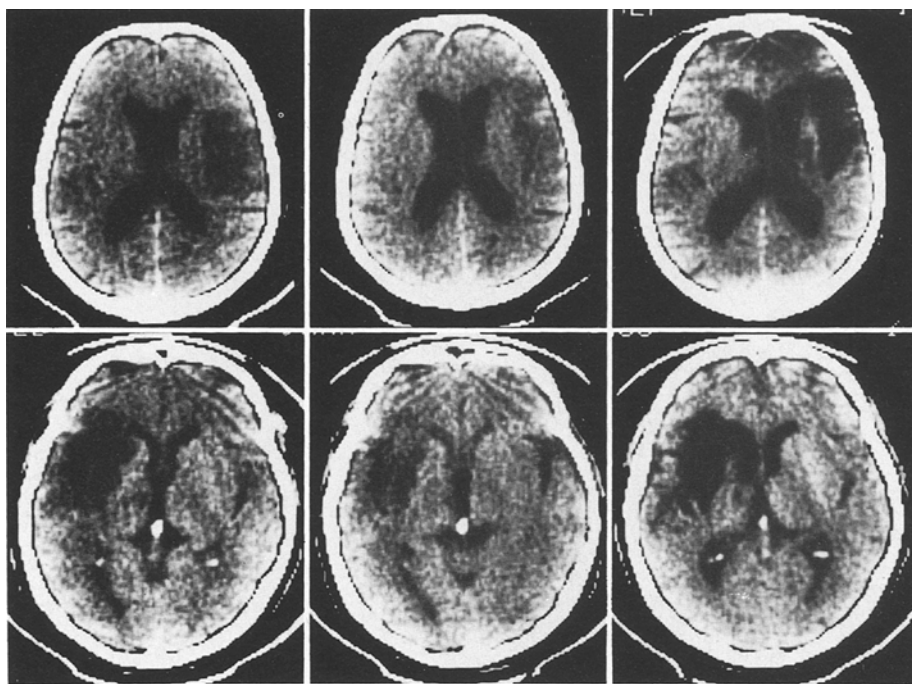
Two cases showing some degree of fogging on CT scans performed during the first week, between the second and third weeks, and 6 months after stroke. The hypodense area is still visible on the second examination, but the density has increased
